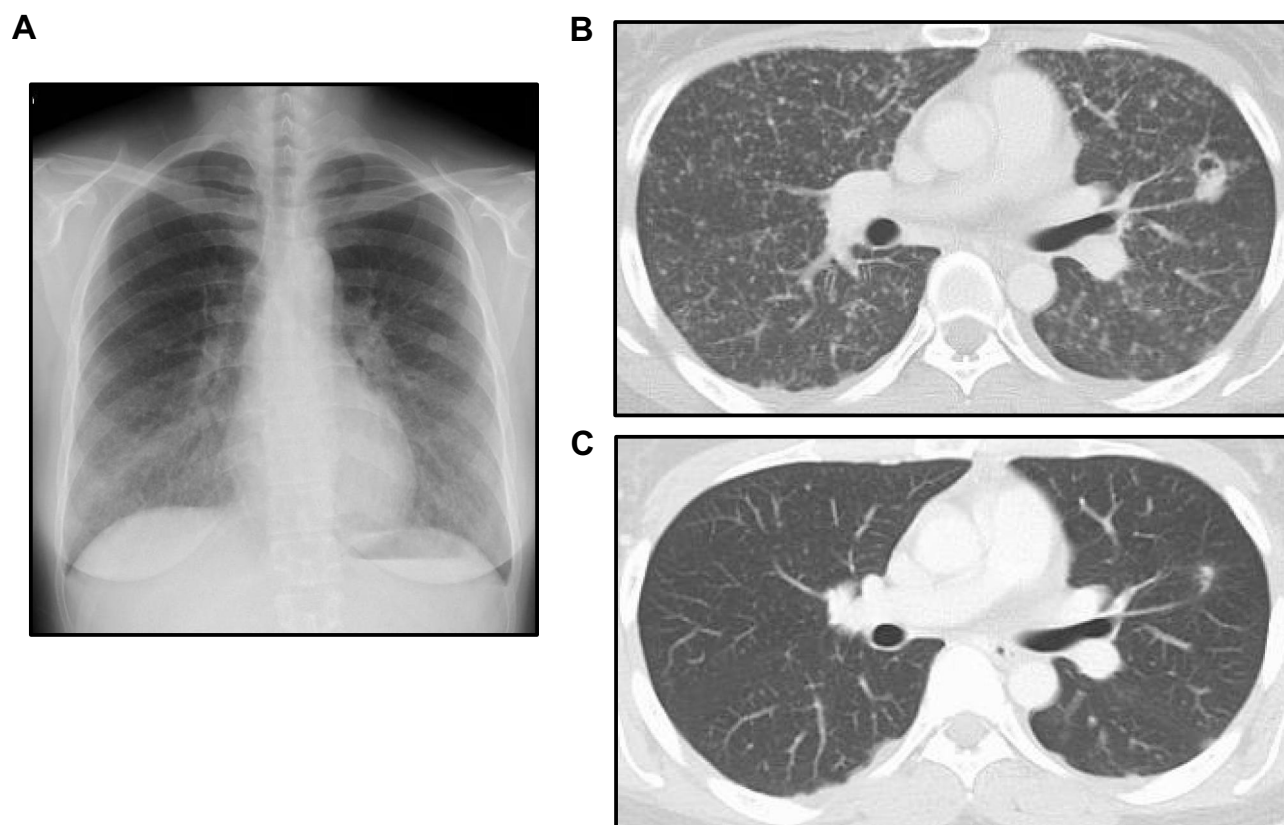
Chest X-ray and CT findings. (A) Chest X-ray at the first visit to our hospital revealed bilateral diffuse shadows and a small cavity in the left lung. (B) CT at the time of EBUS-TBNA showed small, discrete, rounded pulmonary nodules of uniform size diffusely distributed throughout both lung fields. A suspected cavitary primary lesion was identified in the left upper lobe. (C) Three months after the start of treatment with alectinib, the miliary metastasis shadows had decreased considerably.
